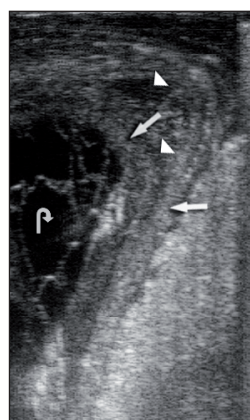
The ultrasonographic appearance of the intussusception. This sonogram was obtained transrectally with an 8-MHz rectal transducer. Mildly echogenic densities represent bowel walls (arrows). Hypoechoic areas among the echogenic linear densities probably represent oedema (arrowheads). The hypoechoic central core indicates the intestinal lumen of the intussusception (curved arrow).
